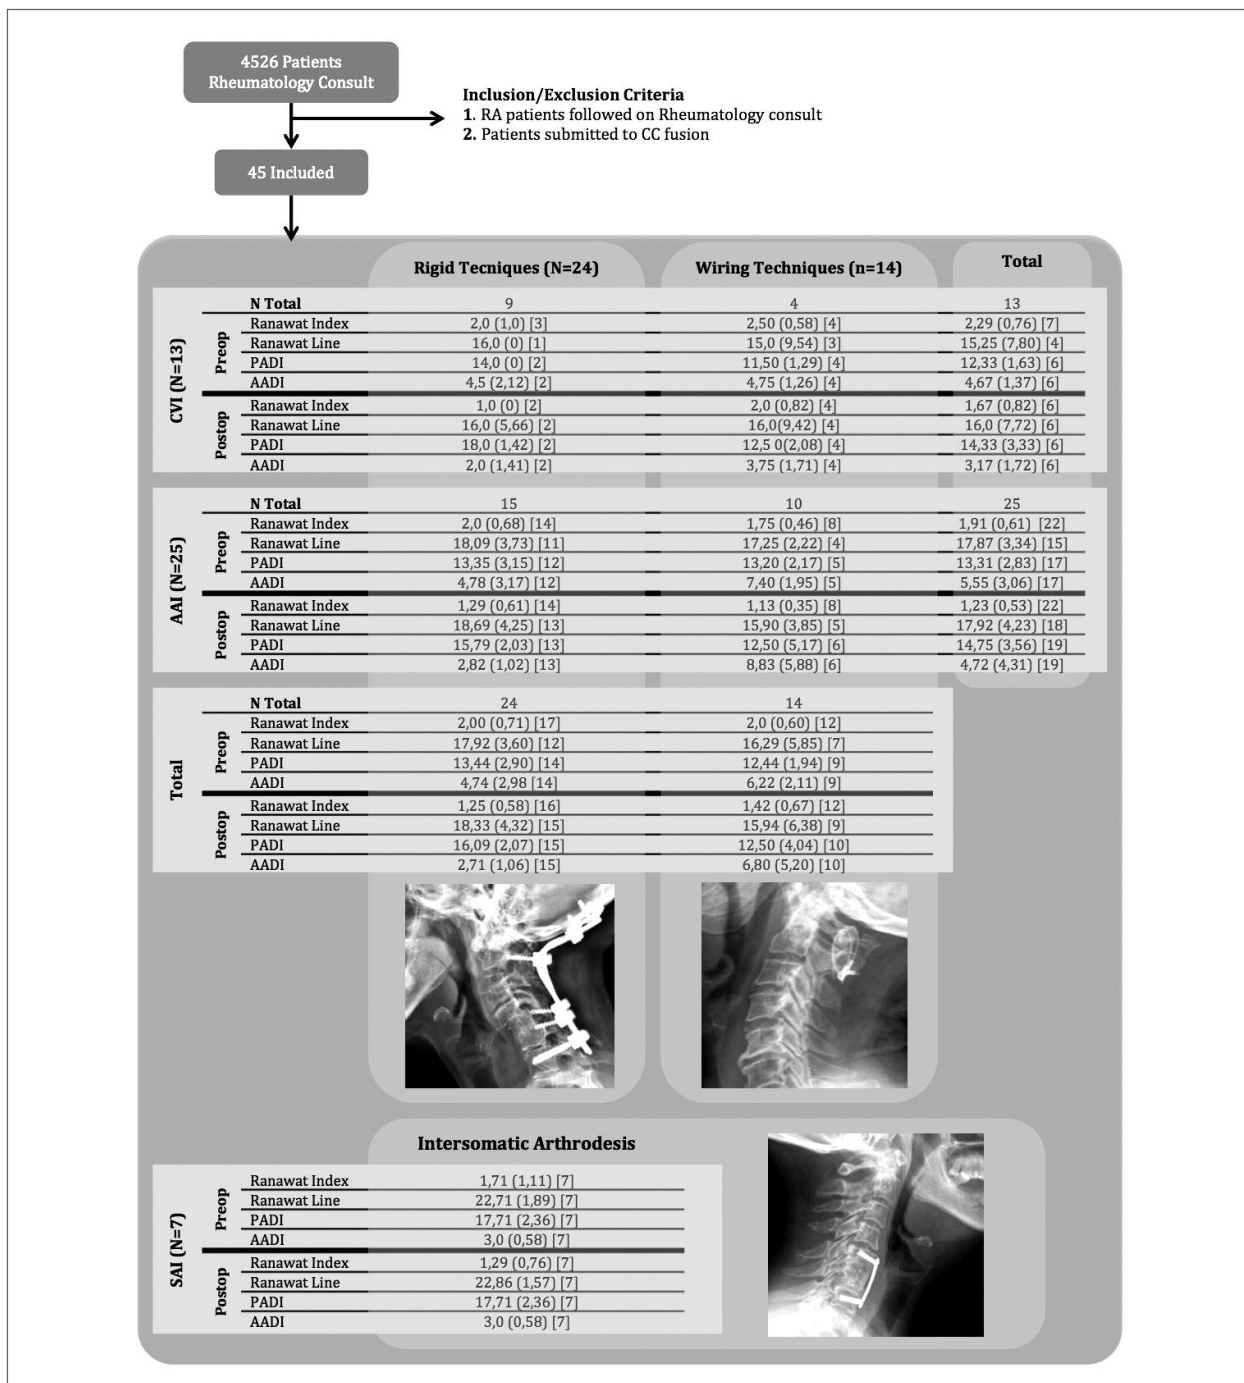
Inclusion process and measured radiographic indexes
